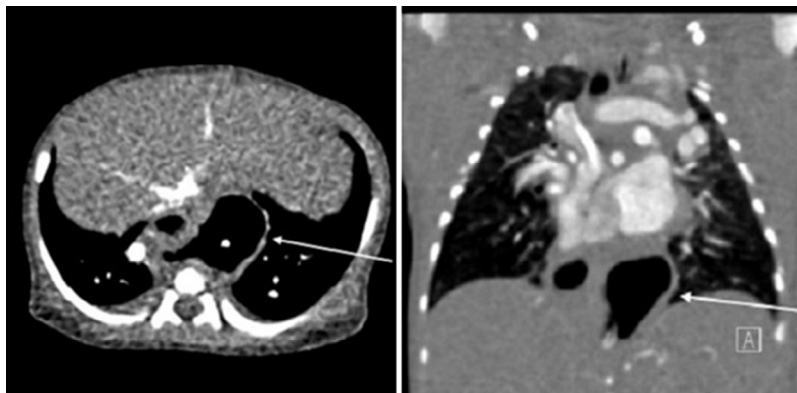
Axial and coronal images from a computed tomography angiography congenital heart protocol obtained on day 1 of life also demonstrate a large hiatal hernia with nasogastric tube in place. The hiatal hernia is marked with arrows.
